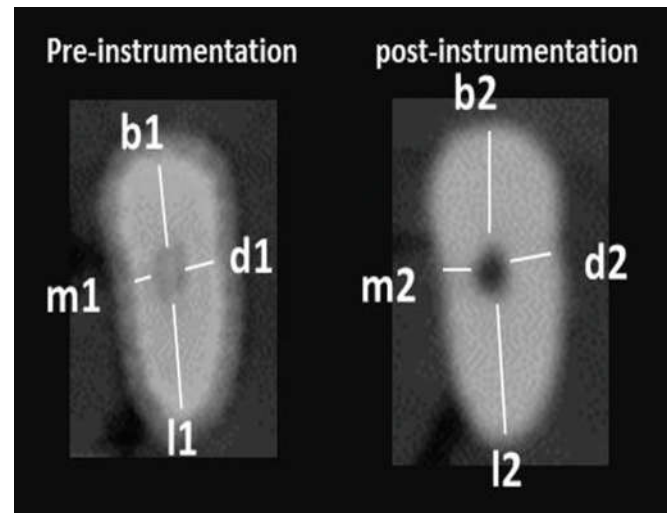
Pre and Post instrumentation Cone-beam computed tomography
